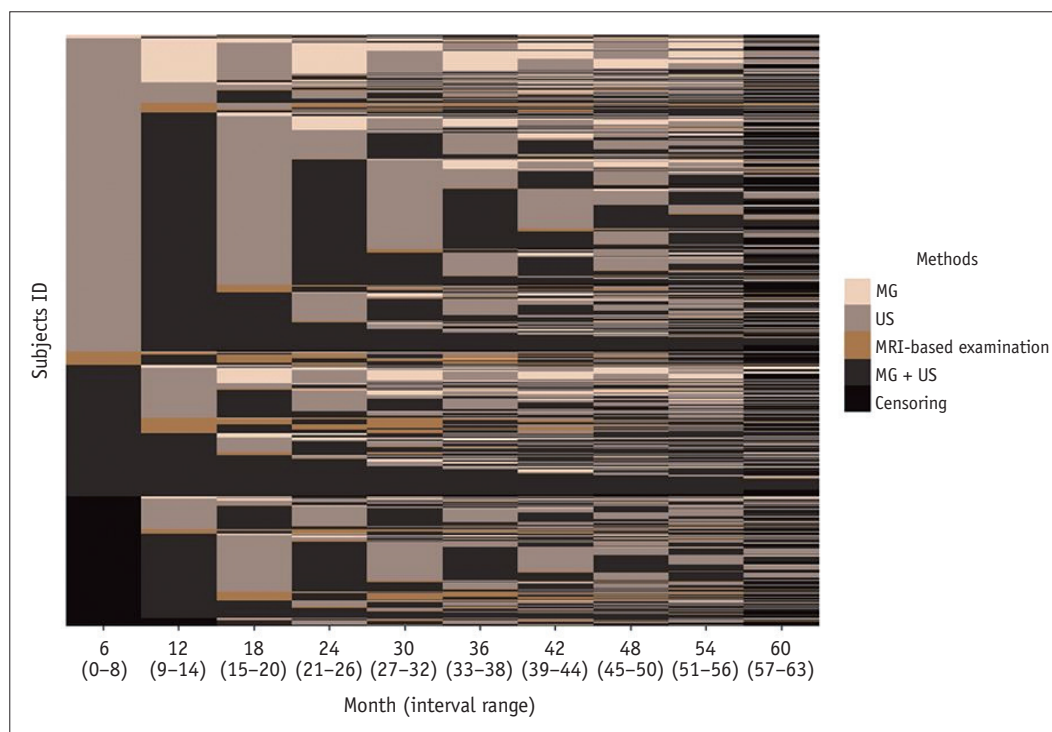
Lasagna plot summarizing the number, imaging methods, and length of follow-up. The colors indicate imaging methods. The columns (x-axis) represent the 5-year follow-up period for each 6-month interval. The rows (y-axis) represent the women included in the analysis. The areas of black color indicate that the woman's follow-up time was censored owing to the absence of surveillance imaging. MG = mammography, US = ultrasound, MRI = magnetic resonance imaging
